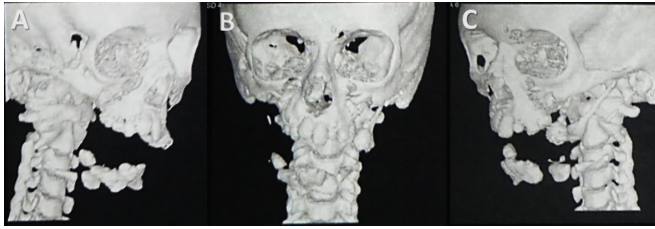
Computed tomography showing extensive osteolytic processes that affected jaw almost completely, leaving only the alveolar portion of the mandibular symphysis and the head of the left jaw presented. (A) Right, (B) front and (C) left view.
